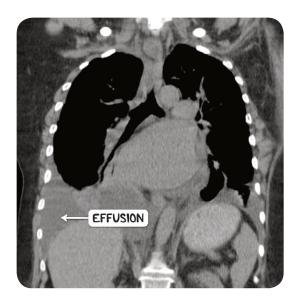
A CT scan of the chest in the coronal plane demonstrating a right sided pleural effusion.
